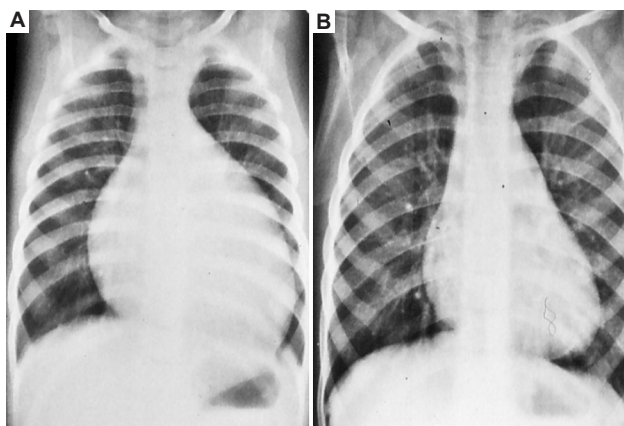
Chest roentgenograms obtained before (A) and at intermediate-term follow-up (B) after balloon pulmonary valvuloplasty demonstrate a decrease in the diameter of the cardiac silhouette. Adopted from Rao.¹⁹
